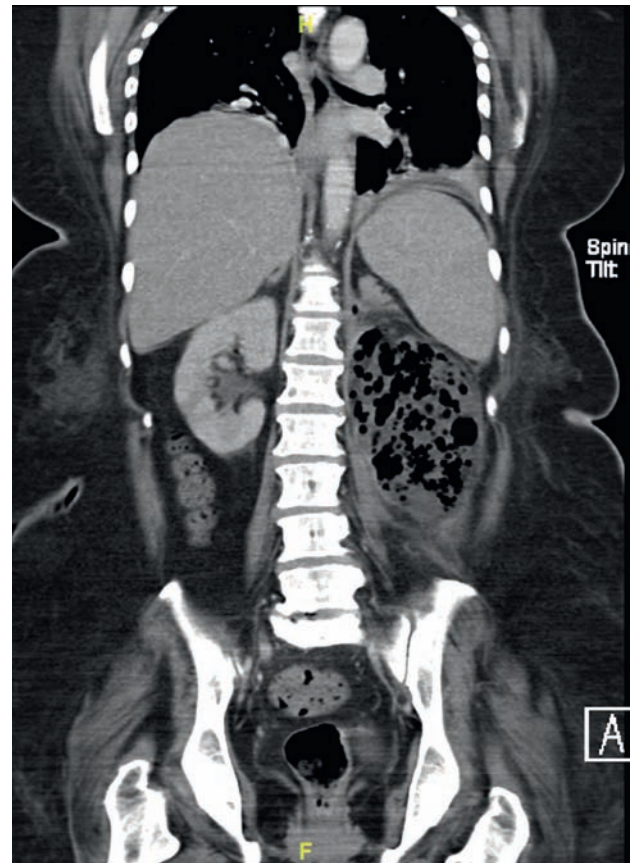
Computed tomography showing features of advanced left emphysematous pyelonephritis with a large perinephric collection.
